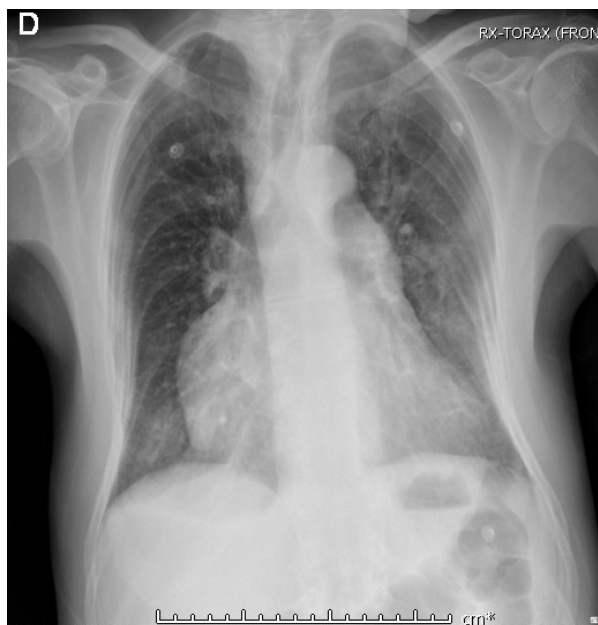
Chest radiograph. Signs of hyperinflation, lung parenchymal scarring, possibly TB-associated.
